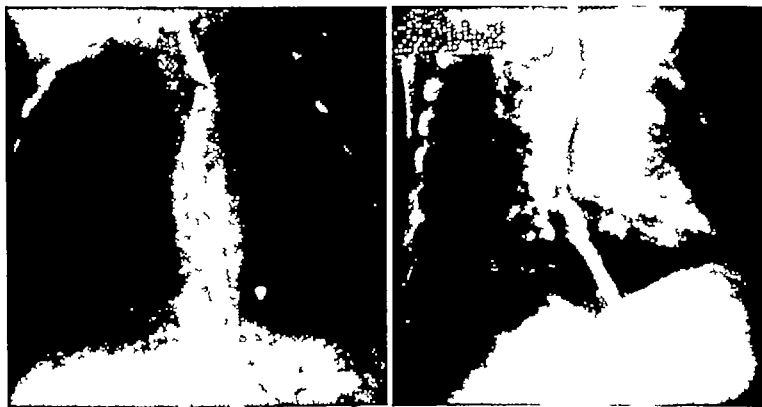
Roentgenographic examination 11 1/4 months after operation. There is no dilatation of the upper portion of the esophagus. The lumen of the esophagus at the level of the stricture is larger than in Figure 6 and is considerably less curved.
